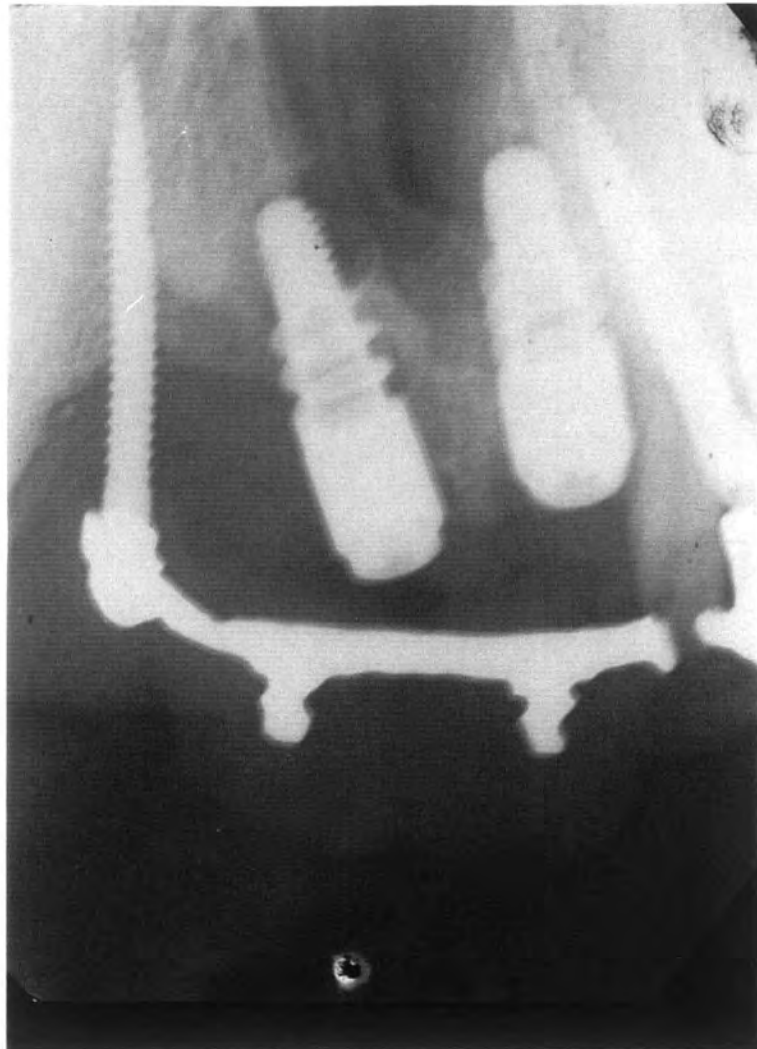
X-ray control of post, with provisional bridge.
